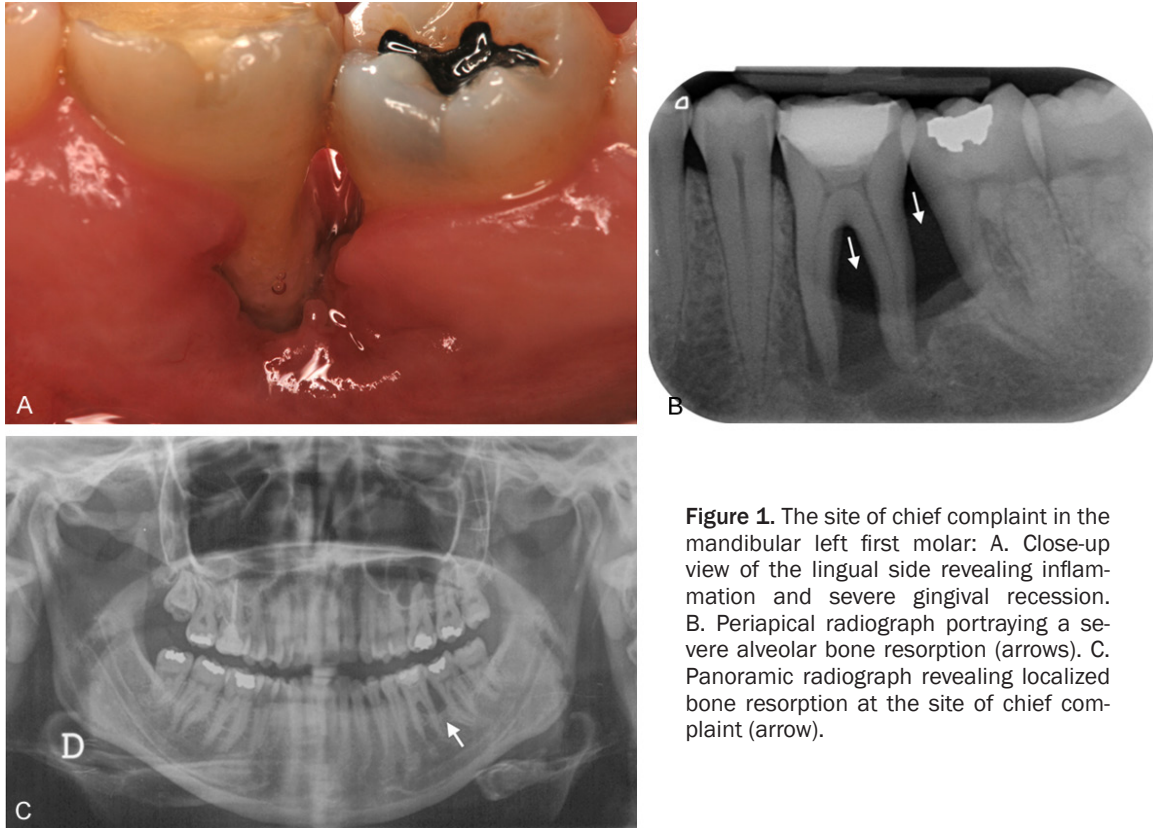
The site of chief complaint in the mandibular left first molar: A. Close-up view of the lingual side revealing inflammation and severe gingival recession. B. Periapical radiograph portraying a severe alveolar bone resorption (arrows). C. Panoramic radiograph revealing localized bone resorption at the site of chief complaint (arrow).
